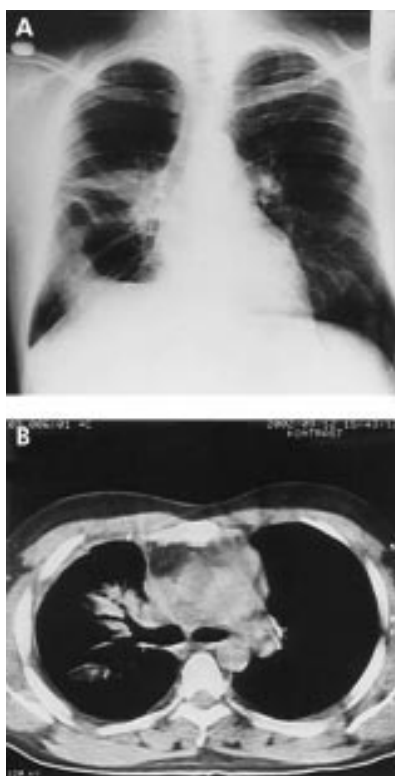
(A) Posteroanterior chest radiograph and (B) CT scan showing marked reduction in the lesions shown in fig 1.
